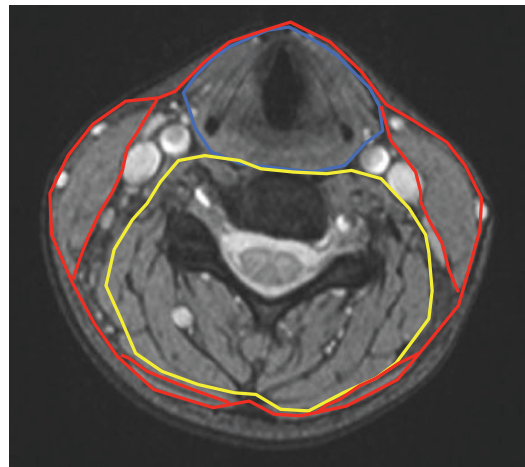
Axial T2W GrE MRI of the infrahyoid neck. Layers of deep cervical fascia: red: superficial; blue: middle; yellow: deep
